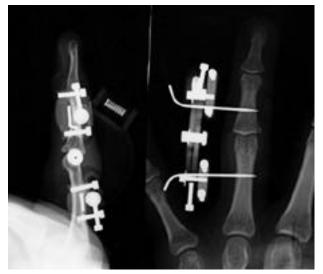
Postoperative radiographs of external fixation with a hinged external fixation fixator, lateral(left) and posteroanteror (right) view. This system can make an early digital motion and a maintenance of fracture reduction.
